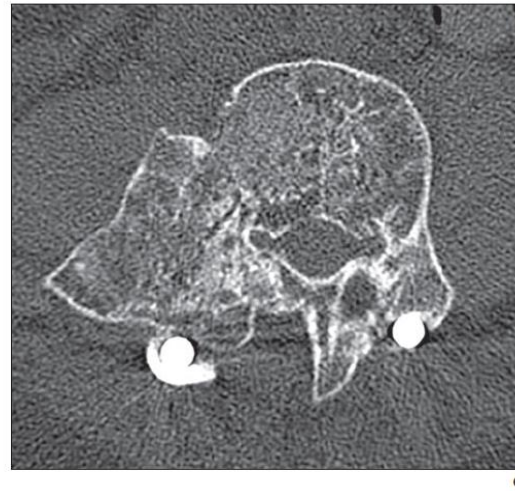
12-year-old girl (patient 2 in Table 1) with L3 aneurysmal bone cyst. A, Axial T2-weighted MR image through patient's large L3 aneurysmal bone cyst shows bone destruction with characteristic fluid-fluid levels (arrowheads). B, Axial CT image at about same level as A shows large, destructive aneurysmal bone cyst. Contrast material with air bubble within large loculated area in periphery of lesion was instilled immediately before infusion of radiopharmaceutical. C, Axial CT image at about same level as B obtained 20 months after radionuclide ablation shows involution and ossification of lesion. Posterior rods are from posterior fusion performed 6 days after ablation to stabilize pathologic fracture.
